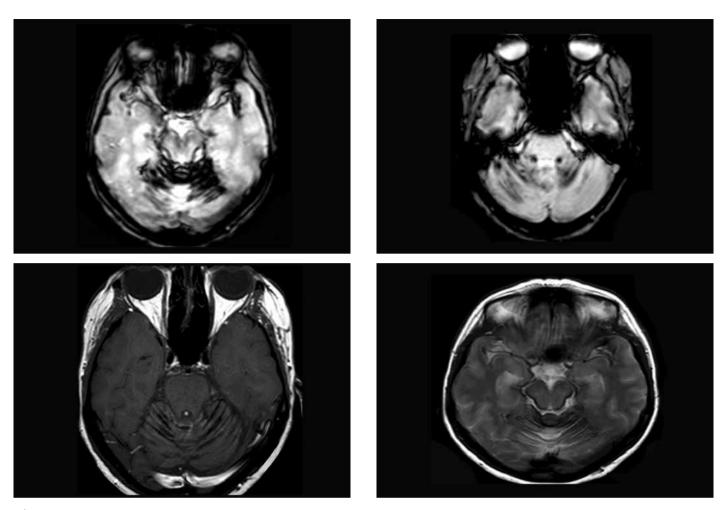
Magnetic resonance imaging showed hypointensity consistent with siderosis along the pial surface of the brain stem and along the folia of the cerebellar vermis, T2 hypointensity appearance surrounding the brain stem, and the 7th and 8th cranial nerves exit zones were present, which was consistent with superficial siderosis
